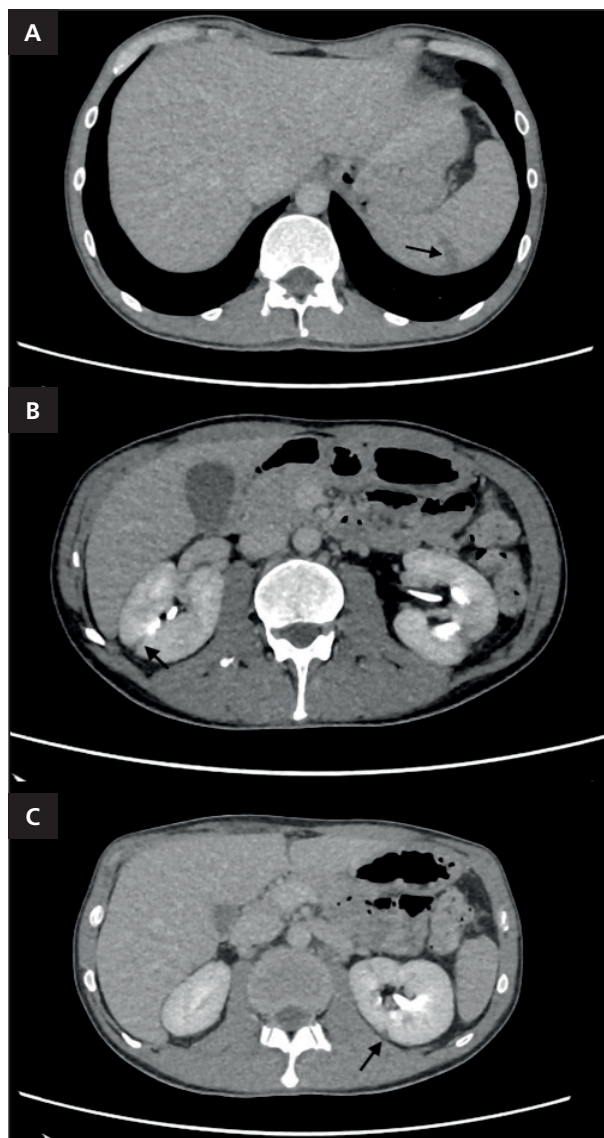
Computed tomography of abdomen. (A) Splenic infarction. (B,C) Bilateral renal infarction
